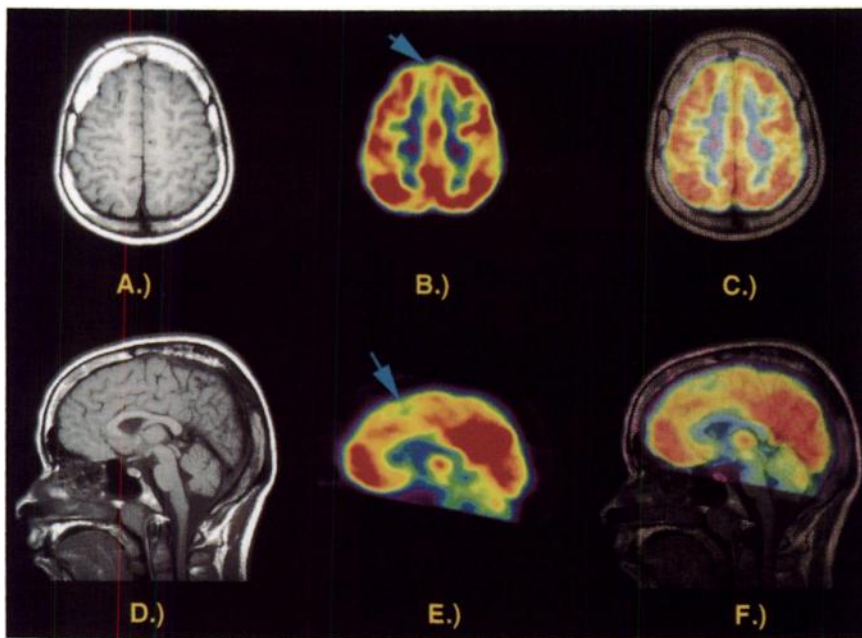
Case study. (A and D) Individual MR images. (B and E) ^{18}F -FDG PET (arrow pointing at hypometabolic area). (C and F) Overlay. A–C show inferior views on axial slices. D–F show medial views on sagittal slices.
